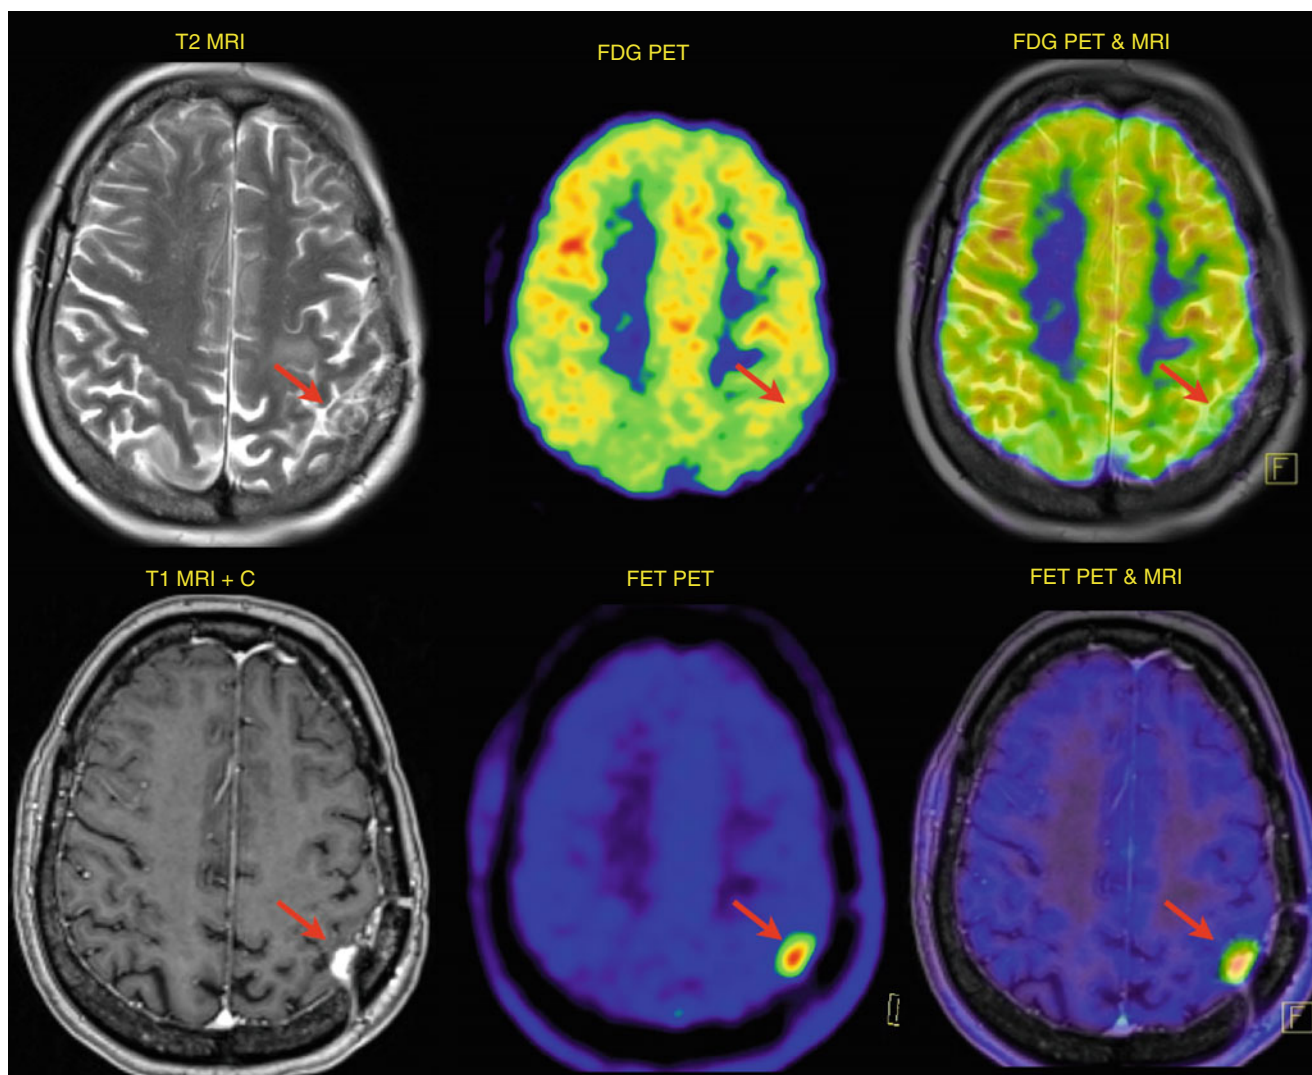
Recurrence of glioblastoma multiforme or treatment damage? Comparison of tumour uptake using FDG (*top*) or FET (*bottom*) in the same patient with glioblastoma multiforme in postoperative follow-up. The metabolic activity in contrast-enhancing area (*red arrows*) is
